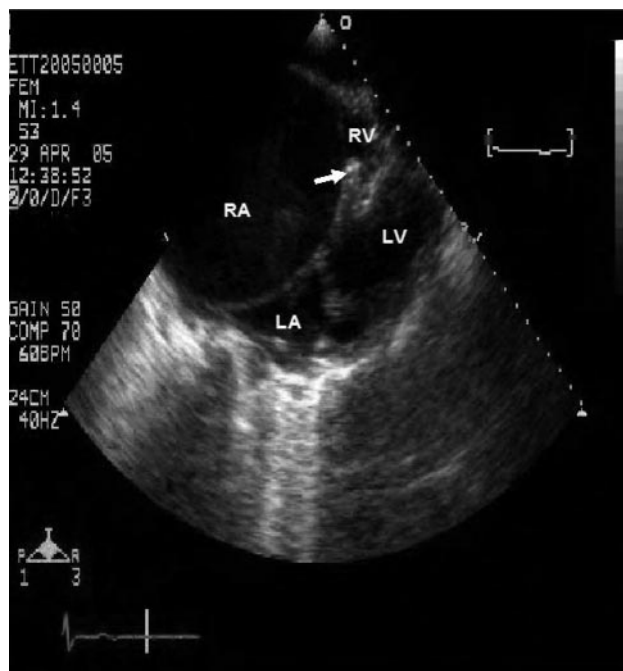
Subcostal echocardiographic images of a child with right-sided EMF, showing aneurysmal dilatation of the right atrium with spontaneous echos (or “smoke”) because of blood stasis and a small right ventricle with calcification at the apex (white arrow). RA indicates right atrium; LA, left atrium; RV, right ventricle; and LV, left ventricle.
